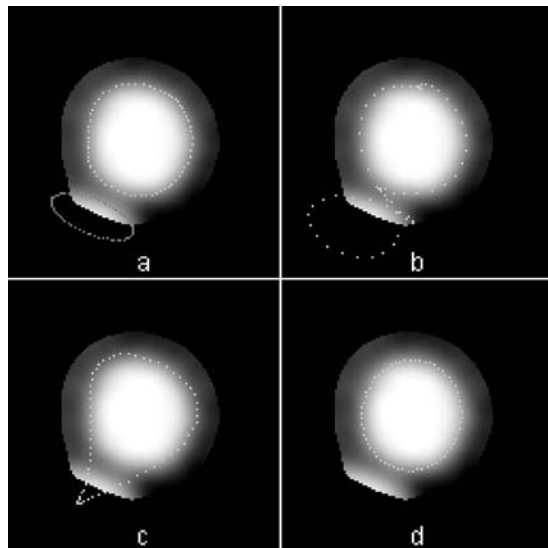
CTA image of the common carotid of patient 2, ninth image of the distal section (Fig. 10 at 29 mm), with a high-intensity structure in the periphery of the ROI (at the lower left). (a) shows the fitted contours with $N=4$ for the central artery and $N=1$ for the peripheral shape. (b)–(d) show the effect of disregarding the peripheral shape; in (b), the same number of Fourier terms ($N=4$) was used as in (a); in (c) $N=2$ and in (d) $N=1$. Each image measures 12.8×12.8 mm². The window center is 200 HU; the window width is 500 HU.
